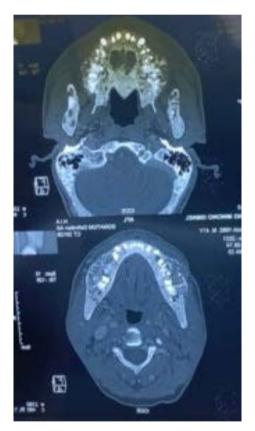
CT axial section, bone hypertrophy of the cranial arch of the maxilla and mandible with mandibular brown tumor.
